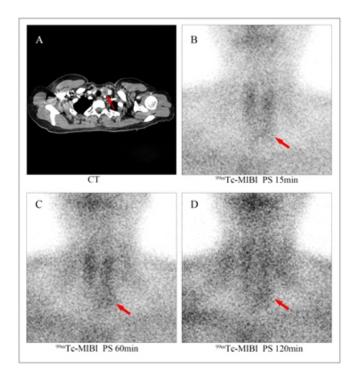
In a 45-year-old woman, a nodule (A, CT, small arrow) behind the lower left lobe of the thyroid was incidentally found on a chest enhanced computed tomography (CT) scan that was performed for pneumonia. The nodule was approximately 2.2x2.0cm, with a regular and clear border and heterogeneous moderate enhancement. Parathyroid adenoma was suspected, even though the serum calcium and parathormone levels were normal. For this reason, dual-phasetechnetium-99m-methoxy-isobutylisonitrile (99mTc-MIBI) parathyroid scintigraphy (PS) was performed the next day. Early imaging (B, 15min, large arrow) and delayed imaging (C and D, 60min and 120min, large arrows) demonstrated abnormally increased uptake in the lower left thyroid lobe. The abnormally increased uptake was more increased in the delayed phase than in the early phase. Thyroid tissue radioactivity was nearly washed out at 120min on delayed imaging. The findings were consistent with parathyroid adenoma.
